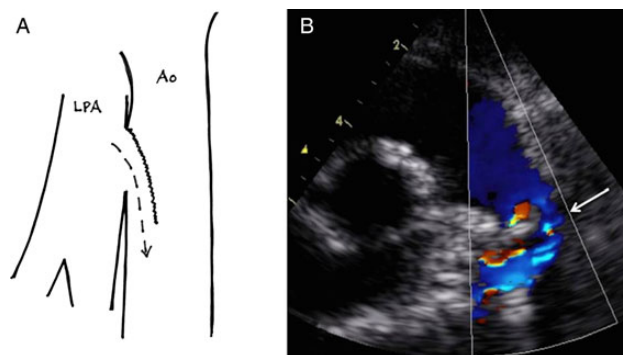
First-in-man use of a surgical unidirectional valved Potts shunt. A surgical valved Potts shunt (A) was used in a 6-year old, 21-kg girl with infrasytemic, severe idiopathic pulmonary arterial hypertension (PAH) receiving a triple combination PAH therapy with bosentan, sildenafil and intravenous epoprostenol. Postoperative echocardiography demonstrated intermittent, unidirectional, right-to-left shunting through the valved Potts (B, white arrow).
